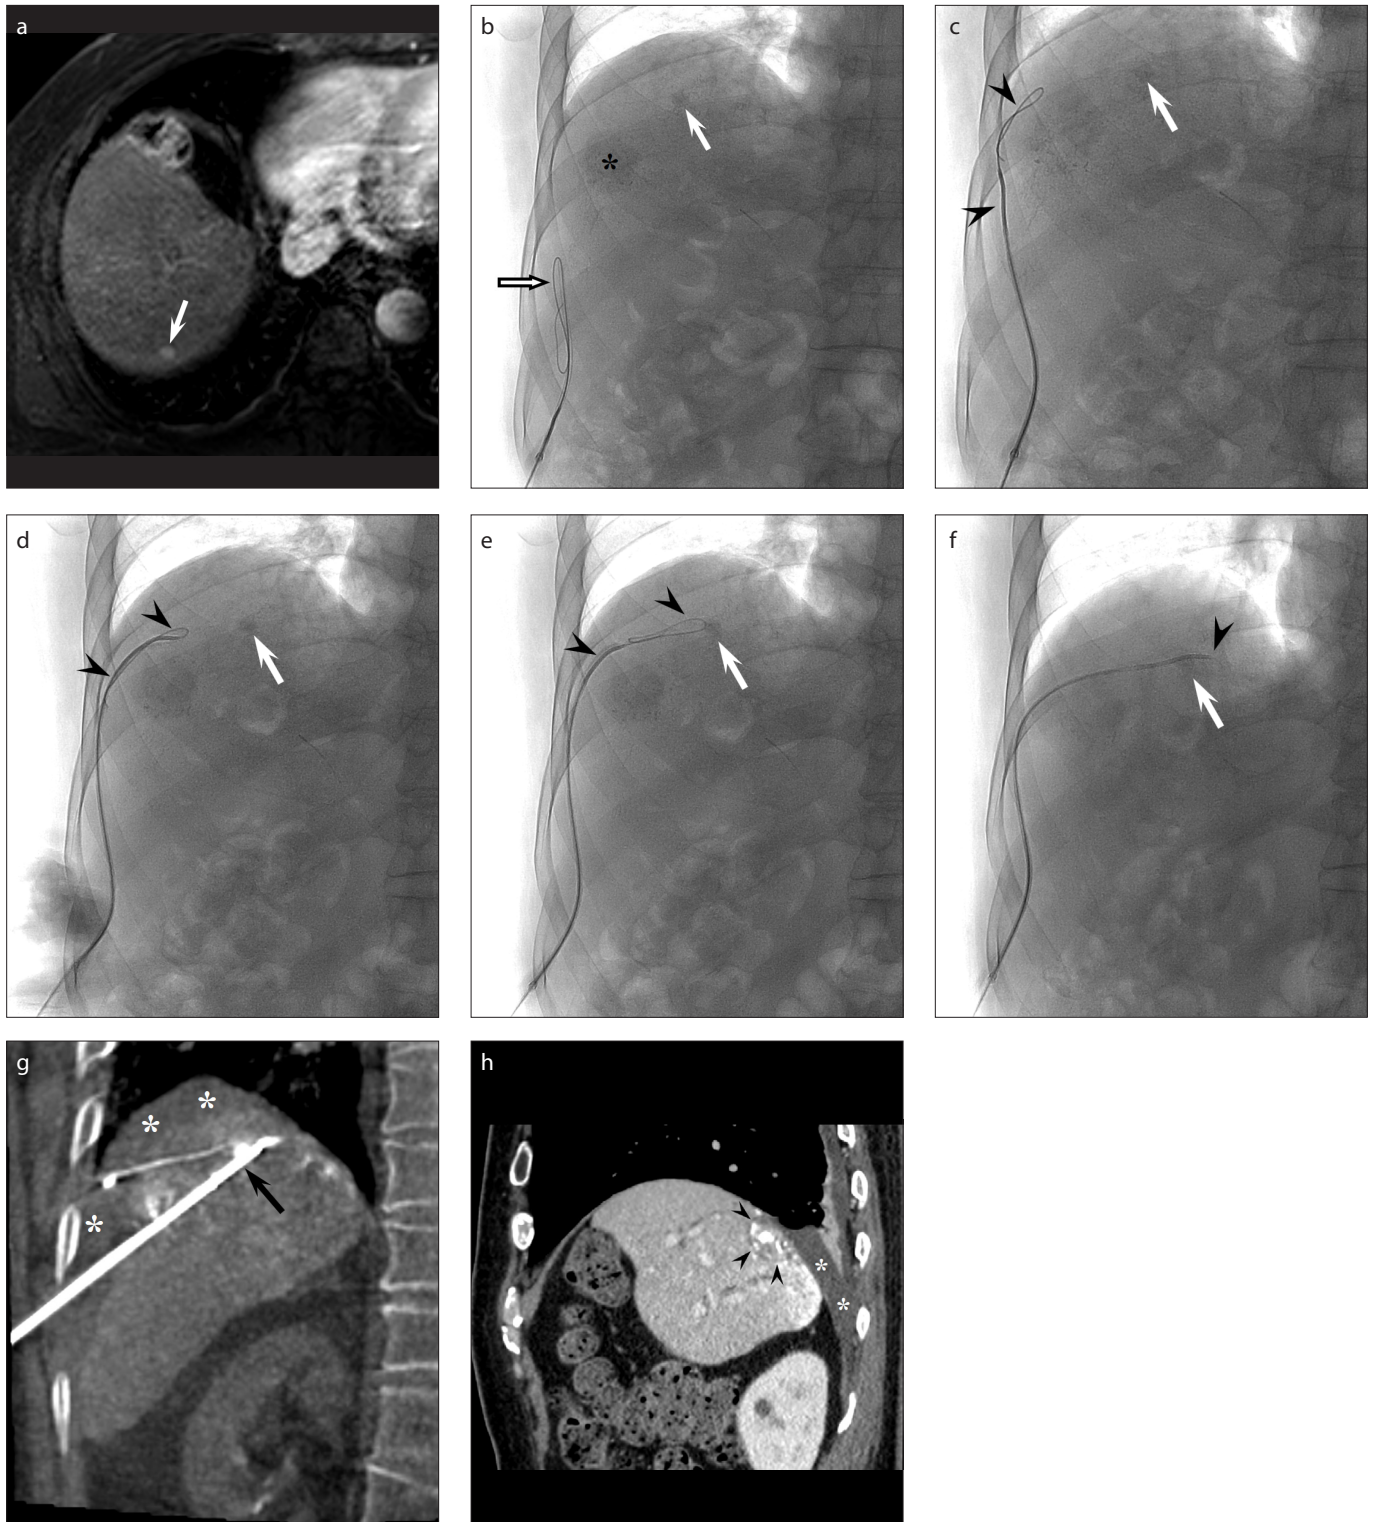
a–h. Creation of GIH to assist RFA for subcapsular HCC in a 65-year-old man with failed artificial ascites due to perihepatic adhesion (case No. 7). Arterial phase axial magnetic resonance image (a) demonstrates a 0.8 cm diameter HCC in hepatic segment VII (arrow), at a 3 mm distance from the diaphragm. Spot image (b) obtained when attempting creation of artificial ascites immediately after iodized oil TACE for the tumor (arrow) shows looping of the guidewire (open arrow) accessed into the perihepatic peritoneal space due to perihepatic adhesion. Also, a previously treated lipiodolized tumor (asterisk) is noted. To create GIH, a 5 F angled tip catheter was advanced into the perihepatic space over the guidewire. Serial spot images of anteroposterior projection (c–f) show sequential advancement of the guidewire–catheter system (arrowheads) with dissection of the perihepatic adhesion to the region near the index tumor with iodized oil retention (arrow). To make appropriate dissection toward the region near the index tumor, the location and direction of the guidewire–catheter system were frequently checked and adjusted on both anteroposterior and lateral projections of fluoroscopy. After reaching the region near the index tumor, D5W was instilled via the catheter tip to make hydrodissection of the perihepatic space near the index tumor. Oblique coronal cone-beam CT (CBCT) image (g) obtained to confirm the final position of RFA electrode tip (arrow) before ablation clearly shows the fluid (asterisks) introduced via the catheter tip. Portal phase sagittal CT image obtained 1 day after RFA with GIH (h) demonstrates complete ablation of the index tumor with iodized oil retention (arrowheads) and no thermal injury to the adjacent diaphragm. Right pleural effusion (asterisks) may represent transdiaphragmatic shifting of the fluid introduced for GIH.
